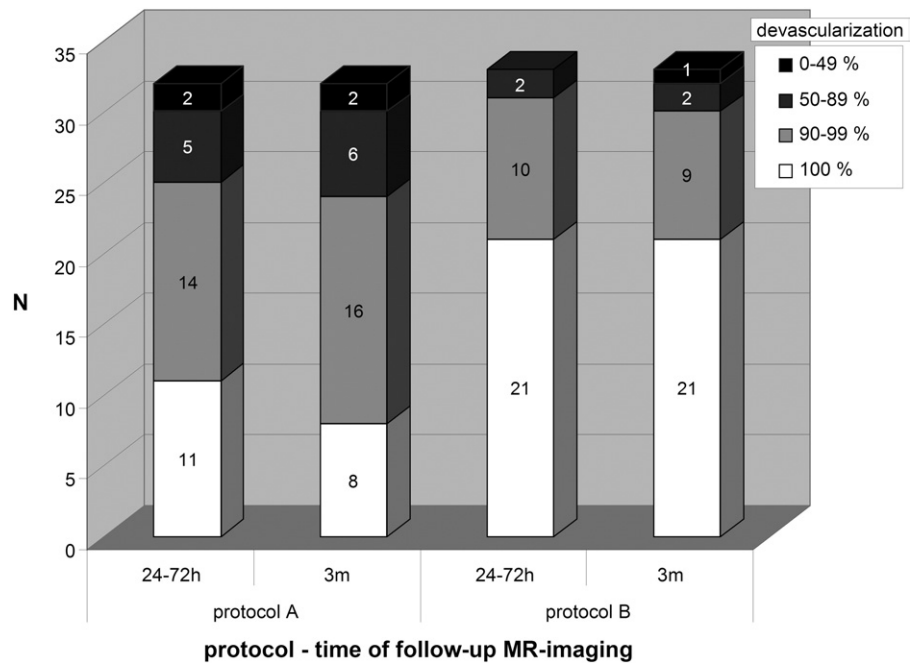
Intra-individual comparison of infarction rate of fibroid tumor load on contrast agent-enhanced MR imaging per protocol at 24–72 hours and 3-month follow-up.
